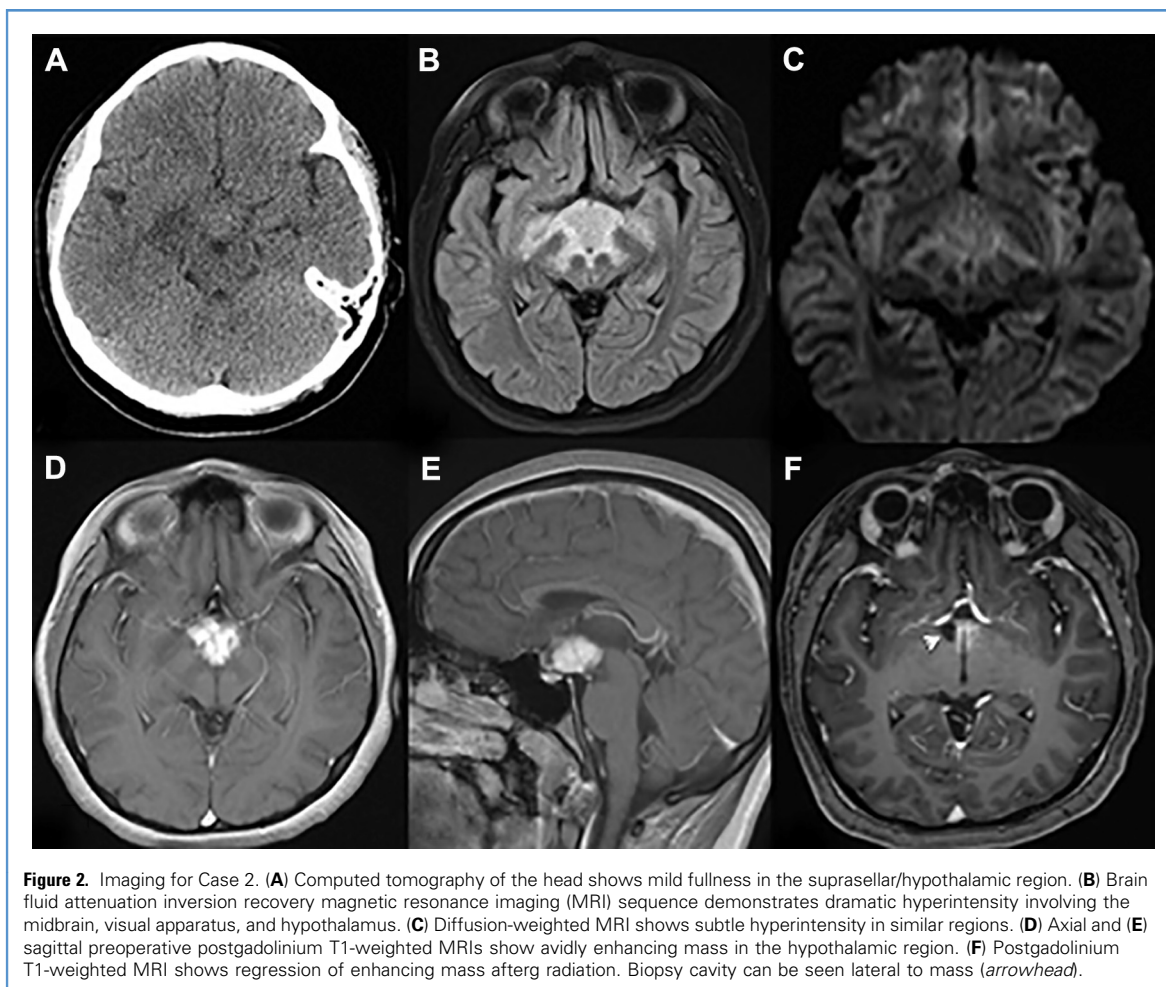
Imaging for Case 2. (A) Computed tomography of the head shows mild fullness in the suprasellar/hypothalamic region. (B) Brain fluid attenuation inversion recovery magnetic resonance imaging (MRI) sequence demonstrates dramatic hyperintensity involving the midbrain, visual apparatus, and hypothalamus. (C) Diffusion-weighted MRI shows subtle hyperintensity in similar regions. (D) Axial and (E) sagittal preoperative postgadolinium T1-weighted MRIs show avidly enhancing mass in the hypothalamic region. (F) Postgadolinium T1-weighted MRI shows regression of enhancing mass after radiation. Biopsy cavity can be seen lateral to mass (arrowhead).
